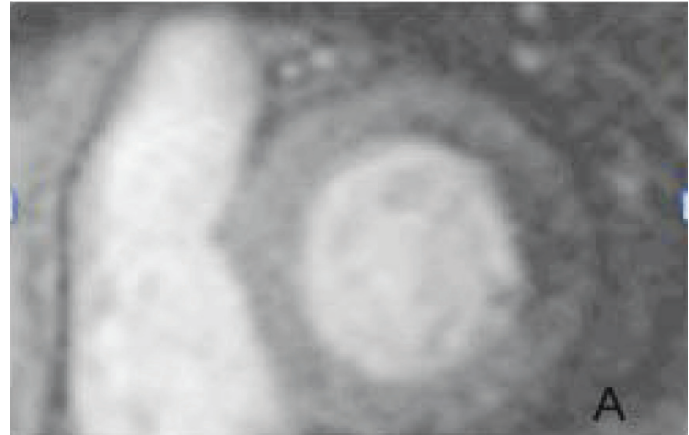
Stress MRI showing perfusion defect and ischemia. Stress perfusion (Figure 1A) showing dark area involving lateral wall suggesting left circumflex territory is chemia. There is a smaller dark area in the corresponding lateral wall on rest perfusion (Figure 1B) suggesting small area of resting perfusion abnormality. Delayed enhancement image (Figure 1C) showing enhancing lateral wall infarct with internal small hypointensity suggesting microvascular obstruction. Region of perfusion abnormality (1A) is more than enhancement (1C) or resting perfusion defect (1B) suggesting infarct with surrounding stress-induced ischemia.
